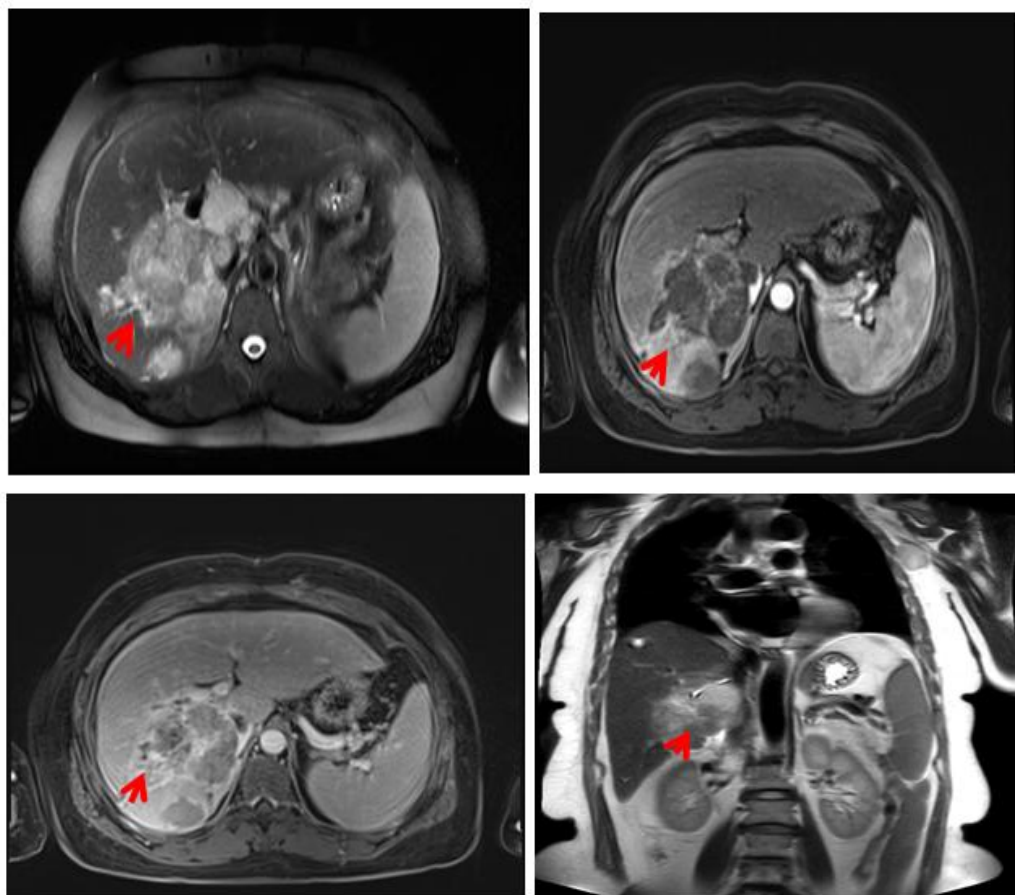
Contrast-Enhanced MRI Findings
